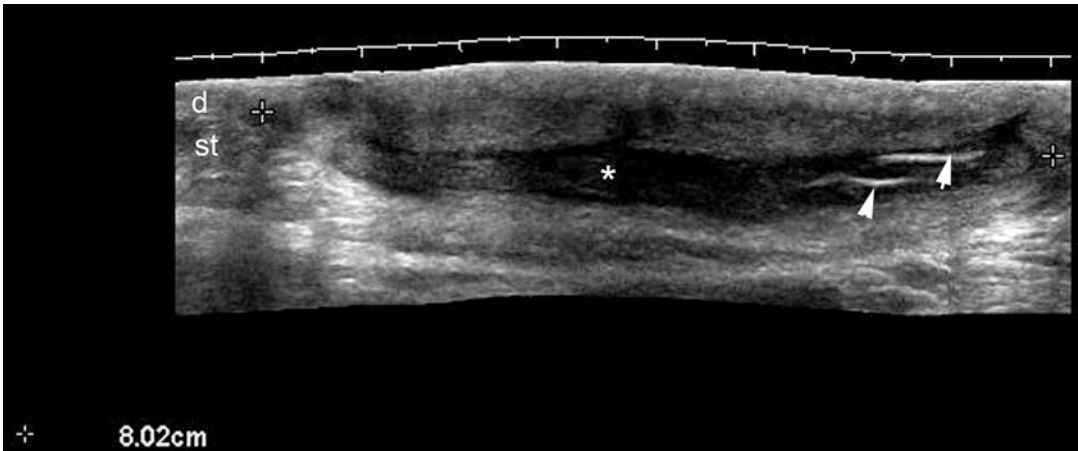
Pilonidal cyst. Grayscale ultrasound (longitudinal view, intergluteal region) demonstrates 8.02 cm long dermal and subcutaneous hypoechoic structure (*, between
